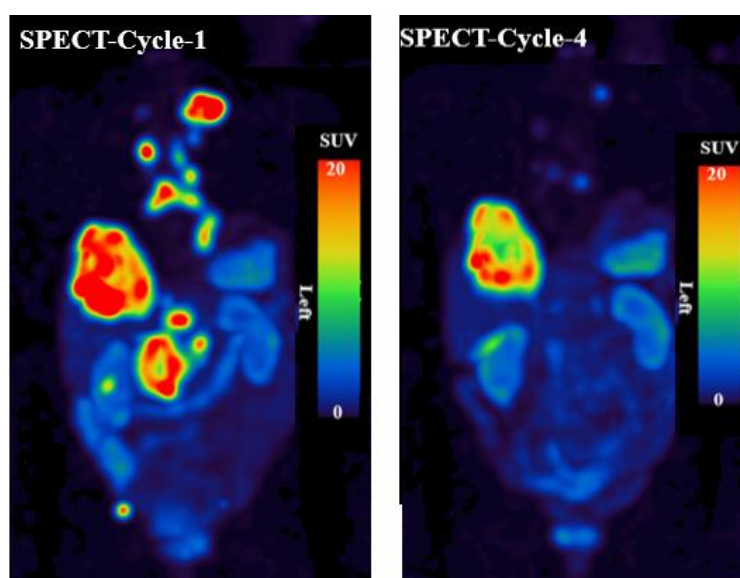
Patient DOTA-20's SPECT/CT maximum-intensity projection (MIP) images 24 hours following PRRT cycles 1 and 4. This patient exhibited a 54% reduction in absorbed dose (mGy), and the total lesion means SUVmax was reduced by 68%.
